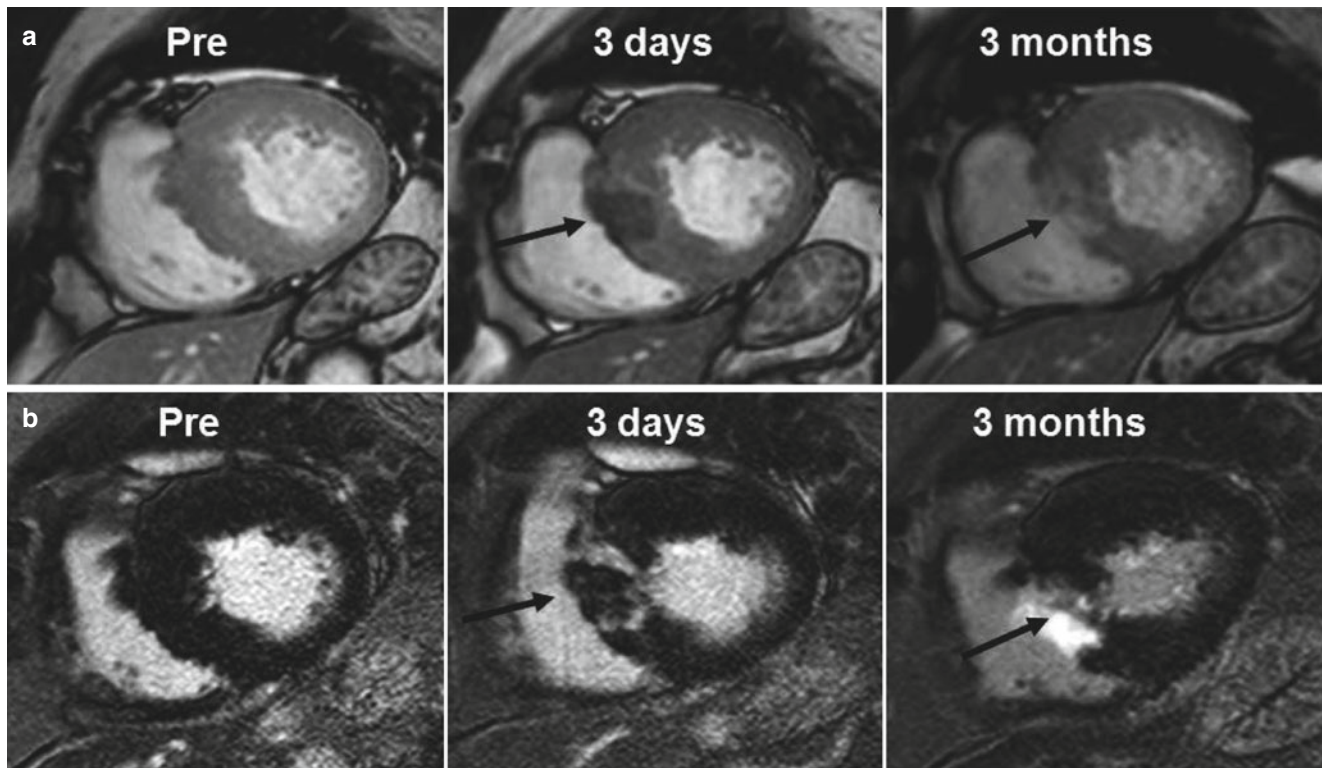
Alcohol septal ablation in patient with asymmetric septal HCM and LVOT obstruction. (a) Sequential short-axis SSFP cine MR images show the progressed wall thinning (*arrows*) due to the infarction after ethanol ablation at the basal septum. (b) Sequential short-axis DE-MR images present the infarcted myocardium at the corresponding areas (*arrows*)
